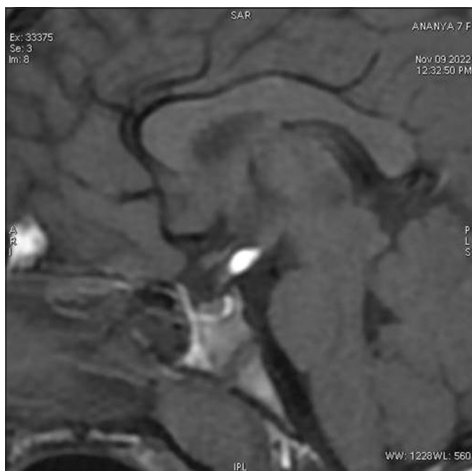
T1 magnetic resonance imaging pituitary showing hyperintense lesion in pituitary stalk.
